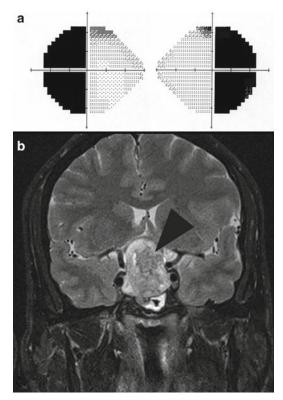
Acute binocular visual loss with bitemporal hemianopia from pituitary apoplexy. The patient also had headaches and diplopia with a left third nerve palsy. (a) Humphrey visual fields showing a bitemporal hemianopia. (b) Coronal T2-weighted MRI demonstrating a large pituitary mass (*arrowhead*) with chiasmal compression and cavernous sinus compression
